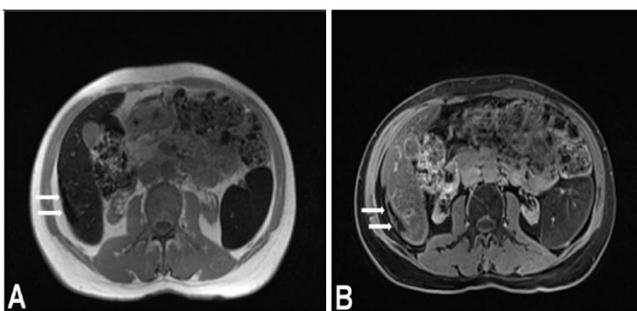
After 6 months of the anti-TB treatment, MR images at T1WI (A) and T1 with contrast image (B) show lesion significantly decreased in size and contrast enhancement compared with the initial MR imaging (arrow).
